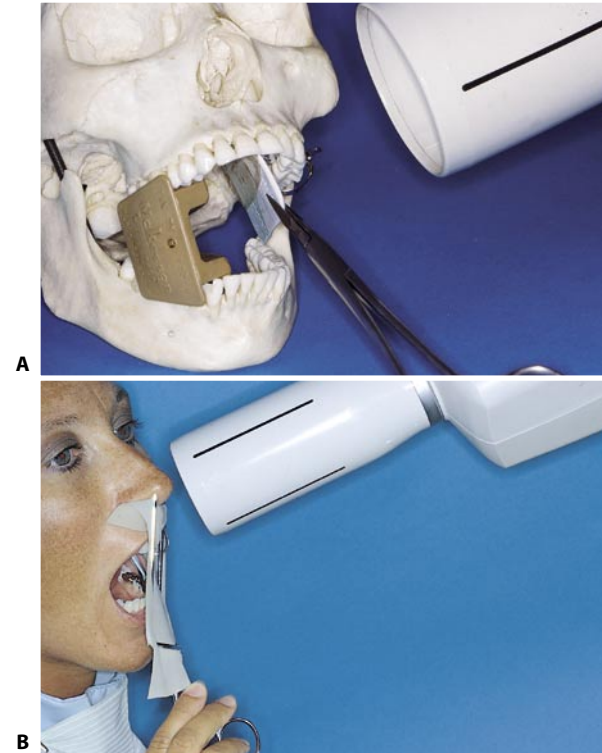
Intraoperative radiograph of the upper premolars. A. The radiograph is held in place by the forceps at an angle of 45° in the mesial angle. B. The forceps are held by the patient with the contralateral hand.
